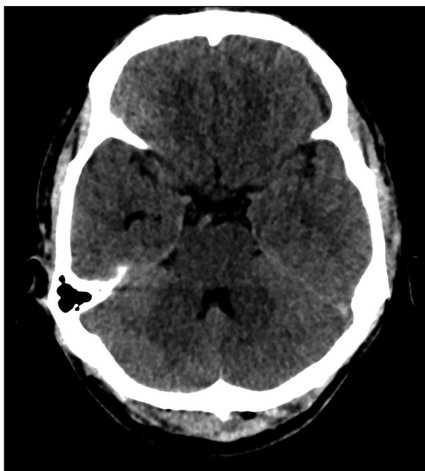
Normal appearance of an axial section of non-contrast computed tomography of the brain
